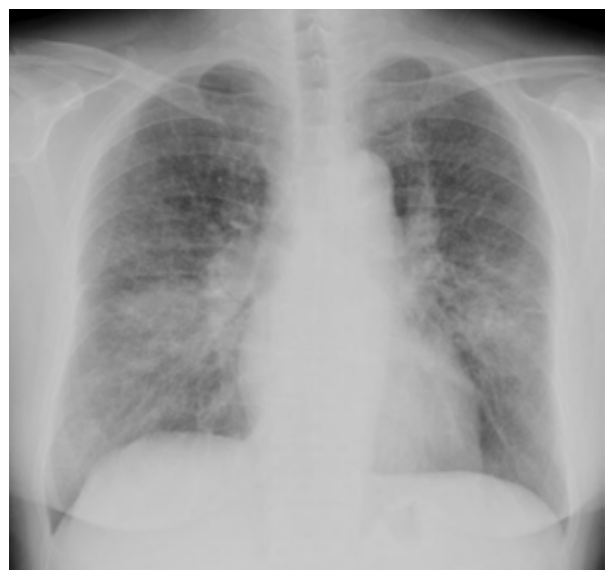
Chest X-ray showing multiple nodular shadows in bilateral lung fields and right hilar lymphadenopathy.
